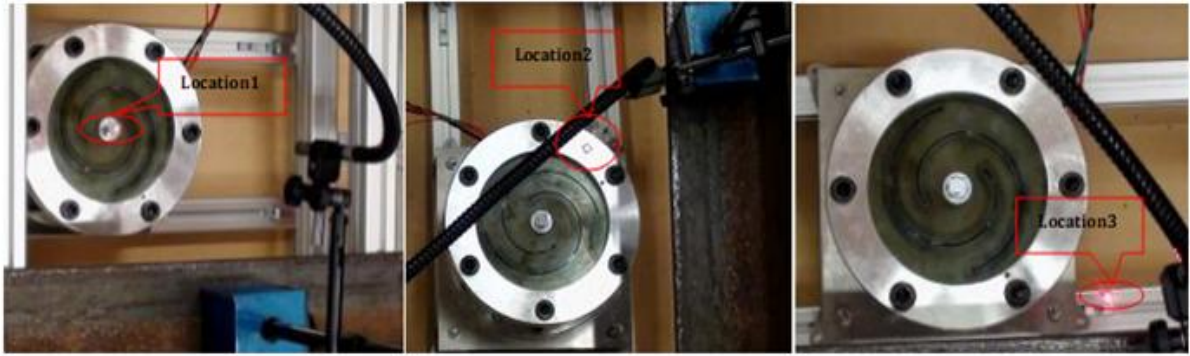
Showing three different locations where Laser Doppler Vibrometer testing were performed for optimising the vibration isolation
